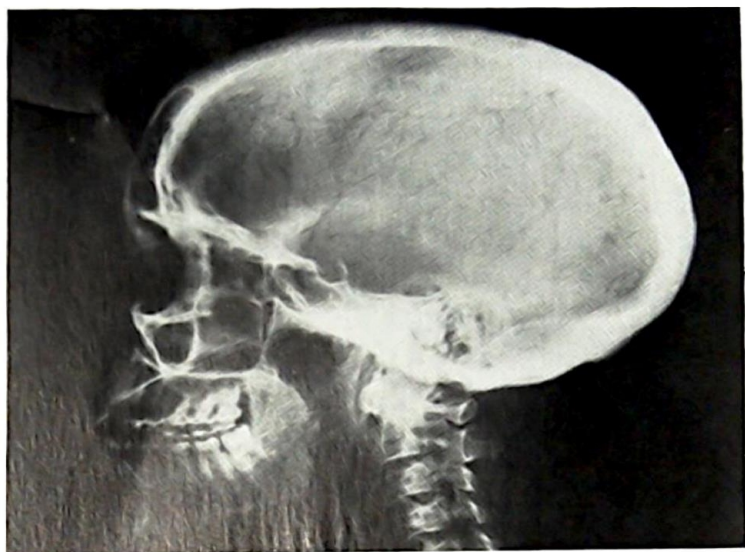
X-ray of patient's sister's skull — showing increased sclerosis of the calvarium, especially at the base of skull.
